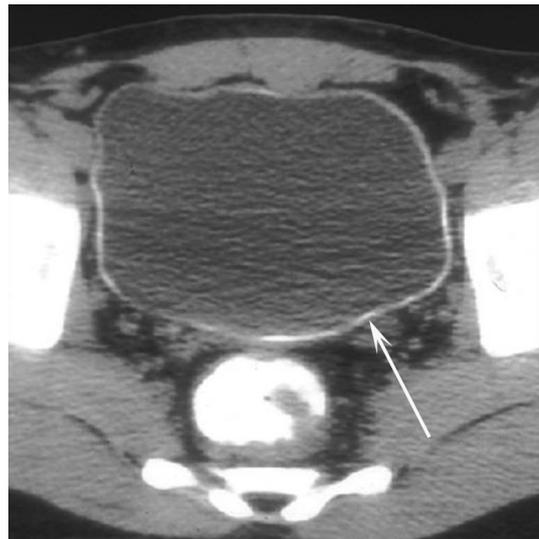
Schistosomiasis. An axial non-contrast CT imaged through the pelvis shows smooth, continuous, linear high attenuation consistent with calcification (arrow) of the entire urinary bladder wall. Note that the bladder has retained its normal capacity. Bladder wall calcification can be a manifestation of several entities including radiation cystitis, schistosomiasis, or tuberculosis, although schistosomiasis is most strongly associated with calcification occurring in a normal-capacity bladder
